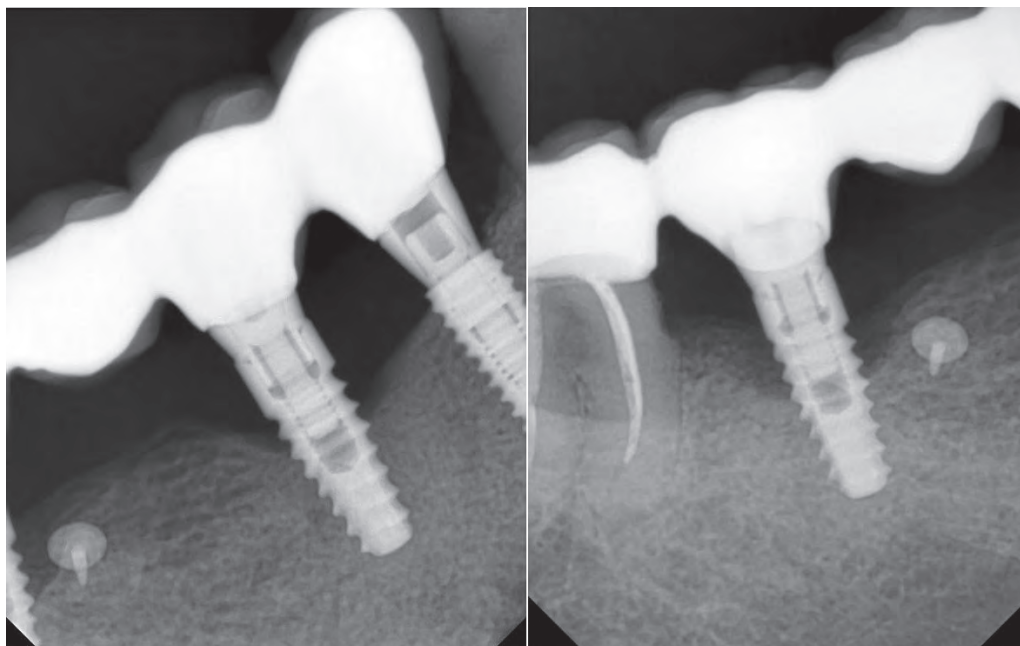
Radiographic bone loss around the implants
